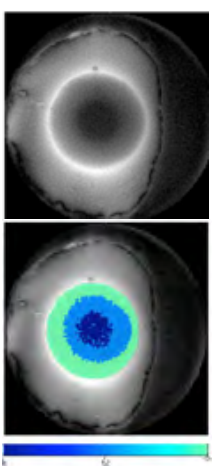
UTE MR image at the end of the first freeze cycle (left) and the same image with the 0, -20 and -40°C isotherms calculated using the curve fit overlaid (right).
